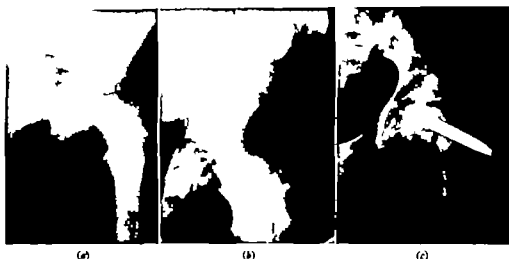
A series of radiographs to show the disaster of wrong application of principles of treatment. (a) The original lesion in a boy aged 13 in 1947. (b) Correction by open reduction and external fixation. (c) An attempt at cervical wedge osteotomy and nailing in 1949 when the bone was so dense that the operation had to be abandoned on account of shock.
